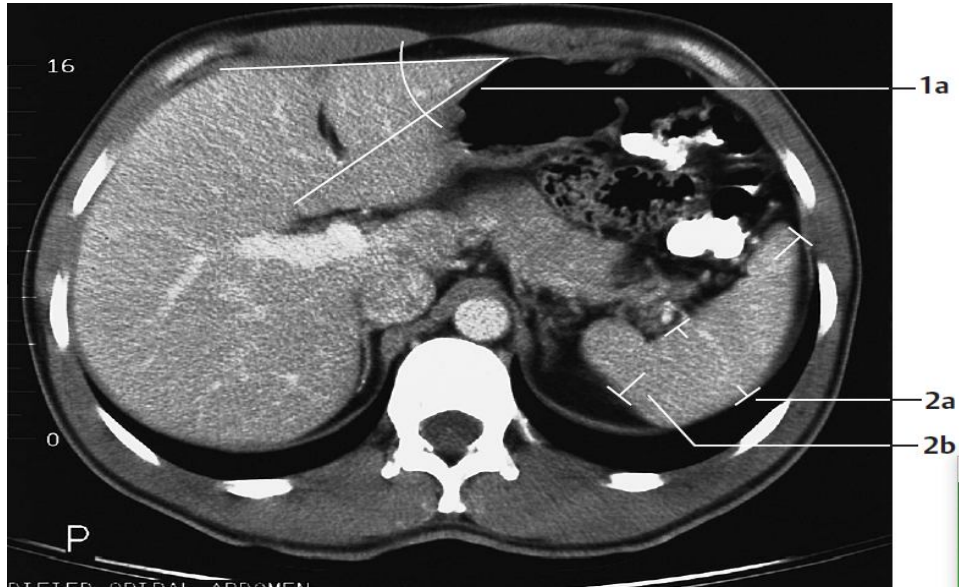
Fig CT liver axial venous phase (1a) Left hepatic angle
